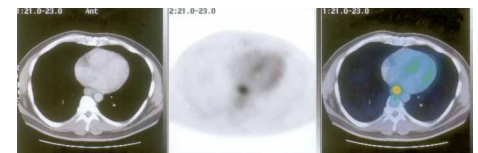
Fusion of the chest CT and PET transaxial imaging shows an abnormal hypermetabolic focus in the posterior mediastinum.
